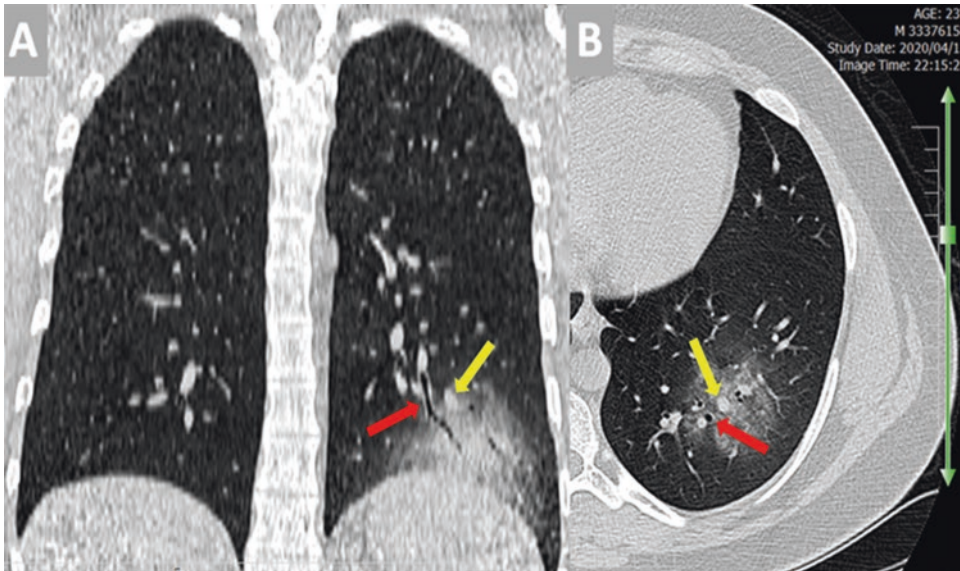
(a) Coronal and (b) axial chest CT scan without contrast in a 23-year-old female with COVID-19 pneumonia shows unilateral and unifocal ground-glass
